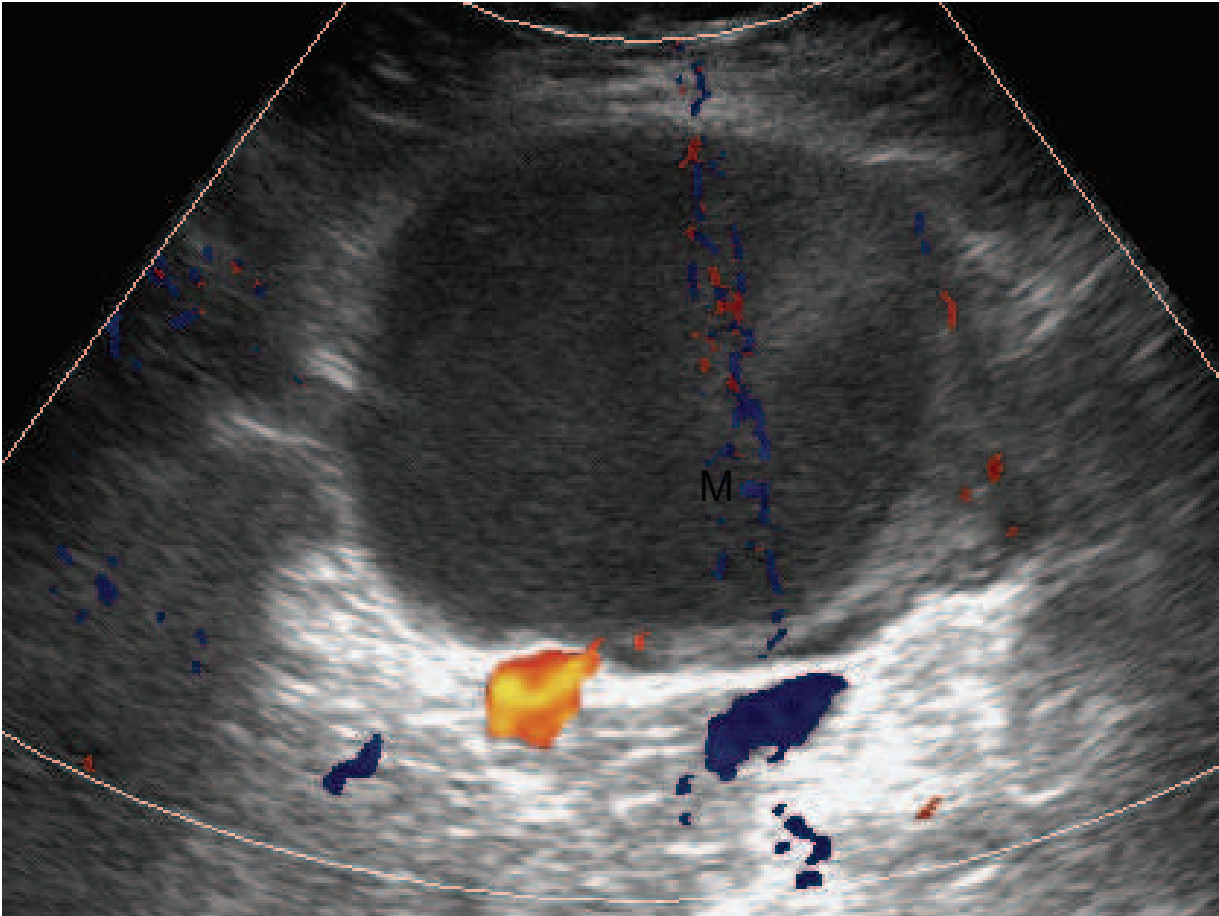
Transvaginal ultrasound of an endometrioma color Doppler image showing mild peripheral vascularity. Internal color signals are likely related to moving internal echos.
